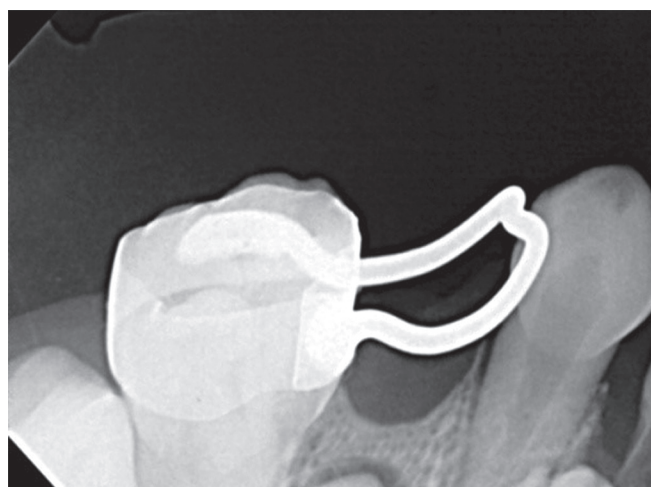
Radiographic image of band-and-loop space maintainer at follow-up
